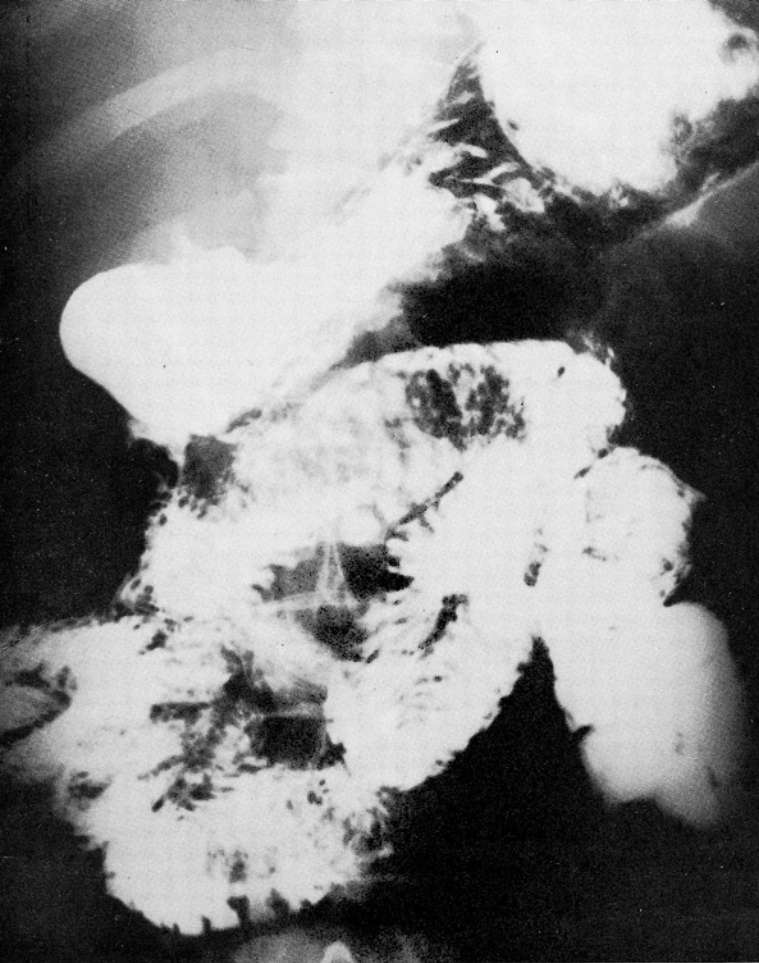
Contrast roentgenogram showing large lesion of jejunum apparently causing intussusception.
